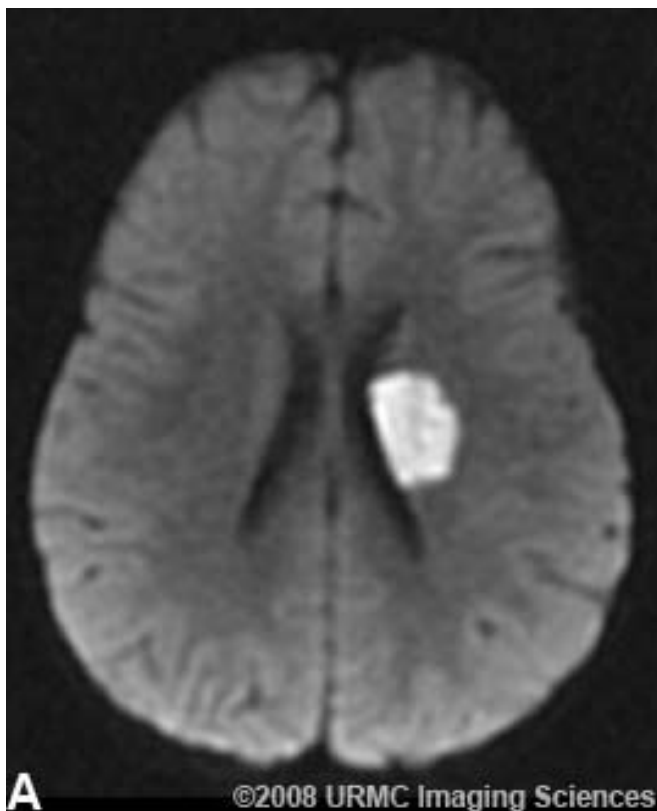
(A) Axial DWI demonstrates high signal within the left corona radiata and body of the caudate nucleus. (B) Low signal is seen in the same region on the corresponding ADC map indicating restricted diffusion.
